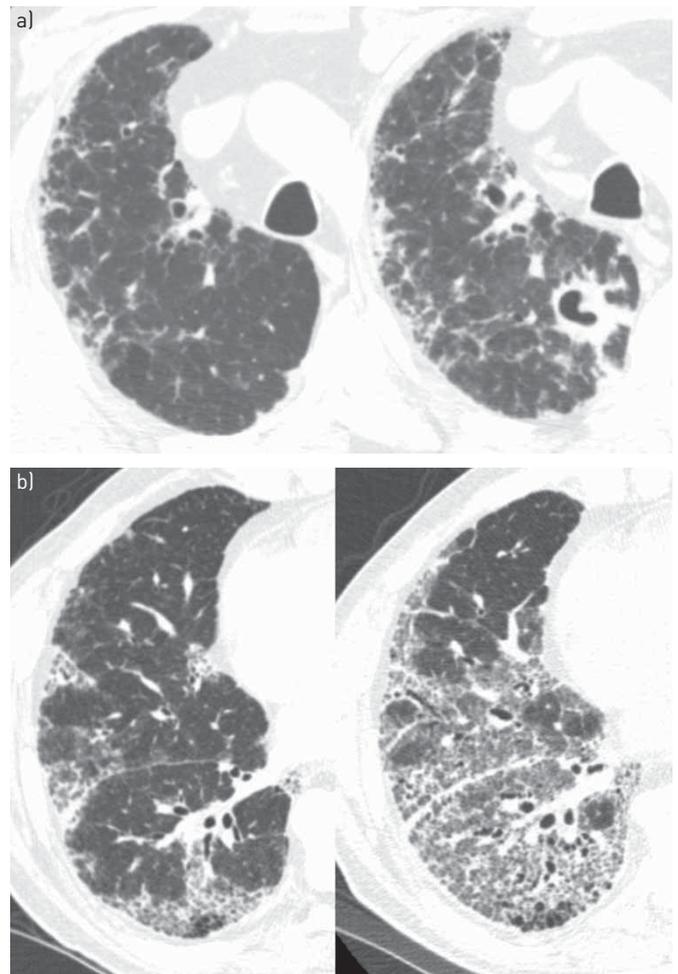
Evaluation of acute symptoms. a) Infection in the setting of idiopathic pulmonary fibrosis (IPF). Baseline high-resolution computed tomography (HRCT) (left) and follow-up HRCT after the development of acute symptoms (right) shows both worsening diffuse lung disease and a new cavitary lesion. Sputum cytology revealed atypical mycobacterial infection. b) Acute exacerbation of IPF. Baseline study (left) shows a usual interstitial pneumonia pattern of fibrosis with subpleural honeycombing and mild reticulation. 1 month later, the patient presented with acute respiratory distress and a new HRCT (right) shows both worsening fibrosis and diffuse ground glass opacity compatible with an acute exacerbation.
